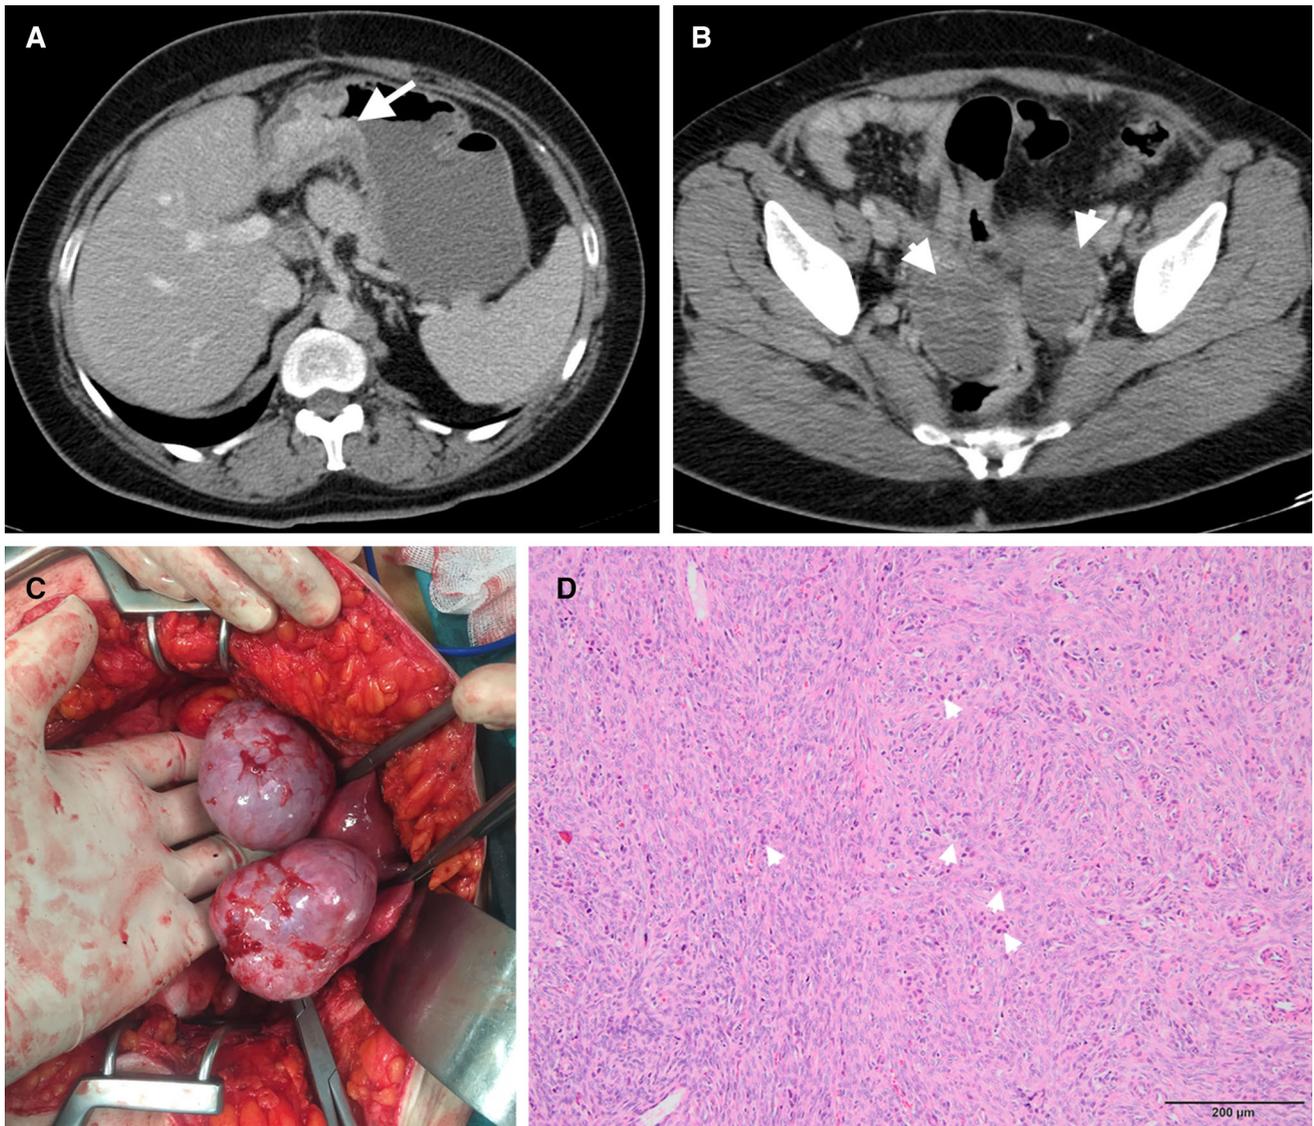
Thirty-five-year-old woman with recently diagnosed gastric adenocarcinoma. A Axial contrast-enhanced CT reveals irregular wall-thickening in the gastric antrum (arrow). B Axial contrast-enhanced CT also demonstrates bilaterally enlarged ovaries (arrowheads) suggestive of metastatic involvement. C Surgical exploration shows
